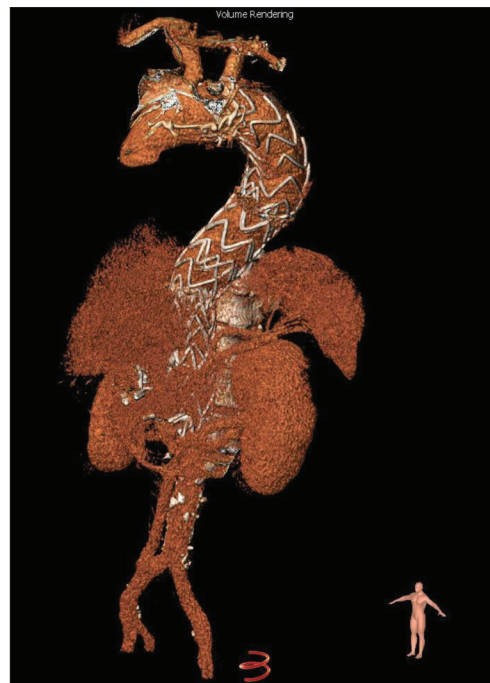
Multidetector computed tomography with angiography in volume rendering reconstruction, five years after thoracic endovascular aortic repair
